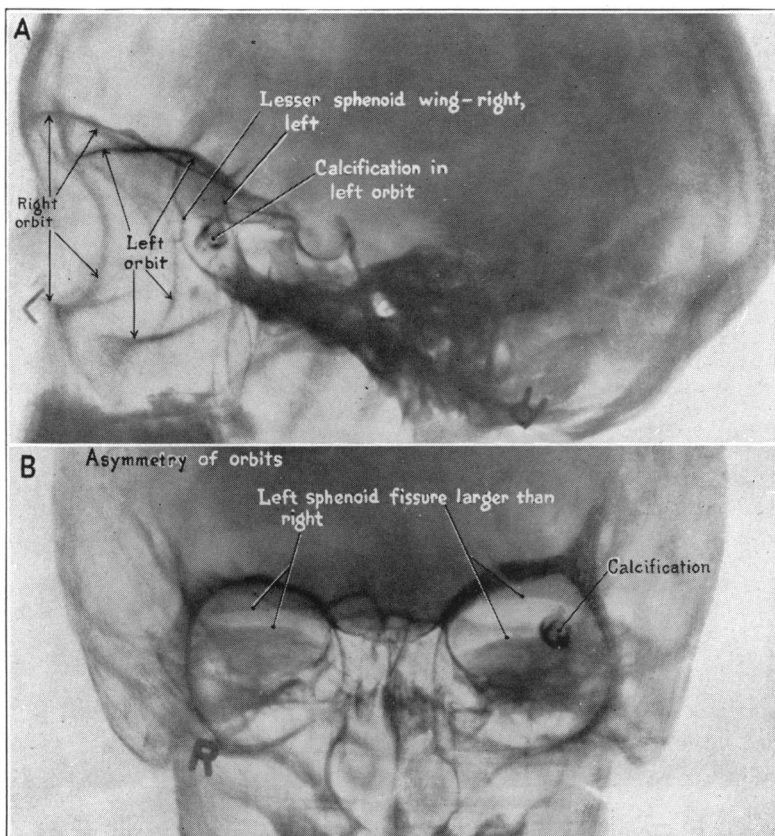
Retouched x-rays of the orbit showing area of calcification and a widening of the left sphenoidal fissure.
